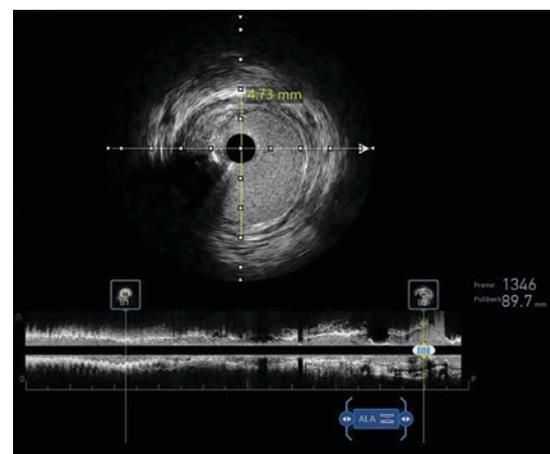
Intravascular ultrasound.
